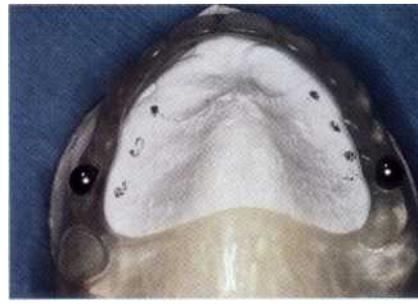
This maxillary stent with radiographic marking balls has two functions; to provide a guide to exact placement of the implants at the time of surgery and to help the surgeon locate areas of maximum bone support as revealed on the radiograph.
